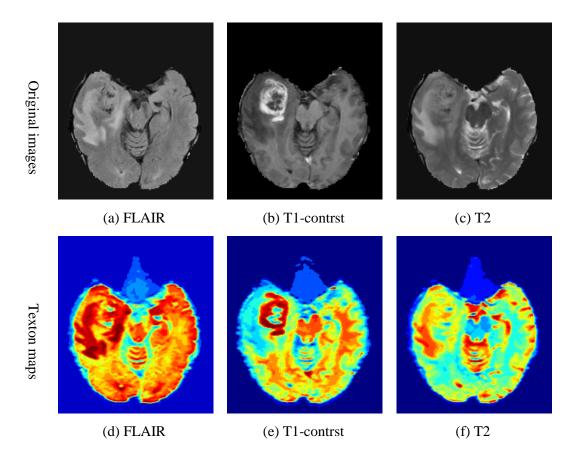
The texton maps generated from the M-MRI images. The figures are shown for challenge case number HG-0309 (ID: 17604) and slice 59. a-c) Original MRI: a) FLAIR, b) T1-contrast, and c) T2-weighted. d-f) texton feature map extracted separately from the protocols: d) FLAIR, e) T1-contrast, and f) T2-weighted.
